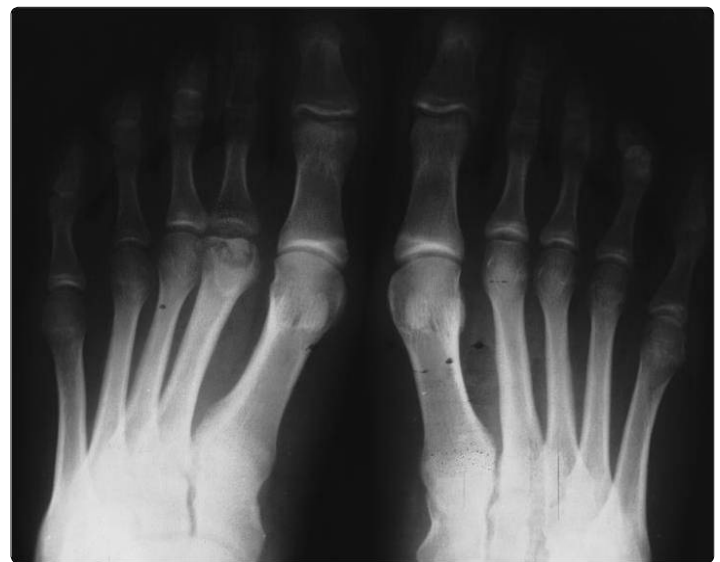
Dorsal-plantar radiograph of a 14-year-old girl indicating unilateral osteochondrosis involving the second left metatarsal head. A stage 3 lesion, according to Smillie's classification, with cartilaginous tearing and detachment of a separated bone fragment associated with central metatarsal head resorption, flattening, sclerosis, irregularity and joint widening, was diagnosed. She participated in karate training since 3 years ago. She reported that metatarsalgia and local edema appeared 6 months earlier.
